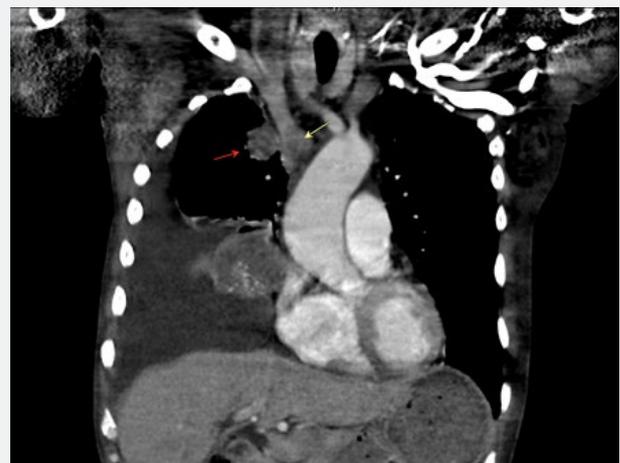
CT scan of the chest with IV contrast showing a mass (red arrow) obstructing the SVC and a distal thrombus (yellow arrow)
